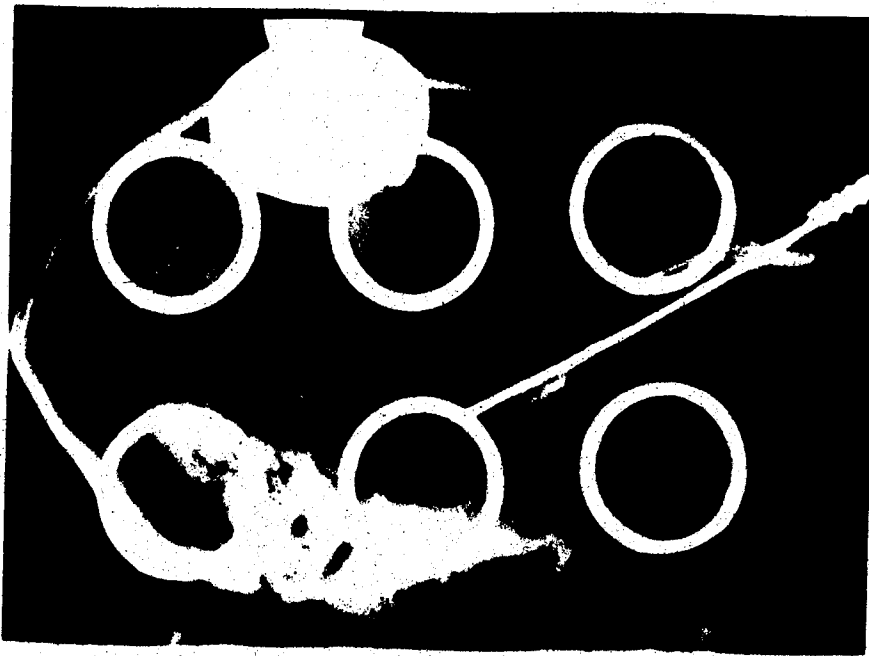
Lateral Radiograph of Template which indicates the discrete areas of the brain "viewed" by the Multiprobe detector.
